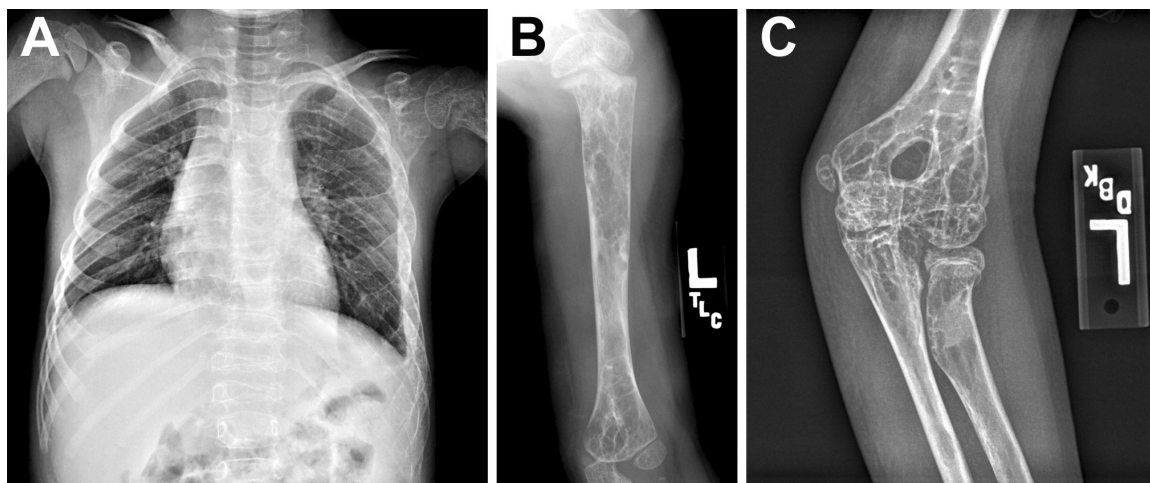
Radiographs showing lytic lesions in the chest and left humerus. (A) Multiple lytic lesions are present in the ribs and right clavicle. (B,C) Radiographs showing lytic lesions in the left humerus. Importantly, cortical bone is still present in the humerus. This pattern of bone loss is more consistent with GLA than GSD.
